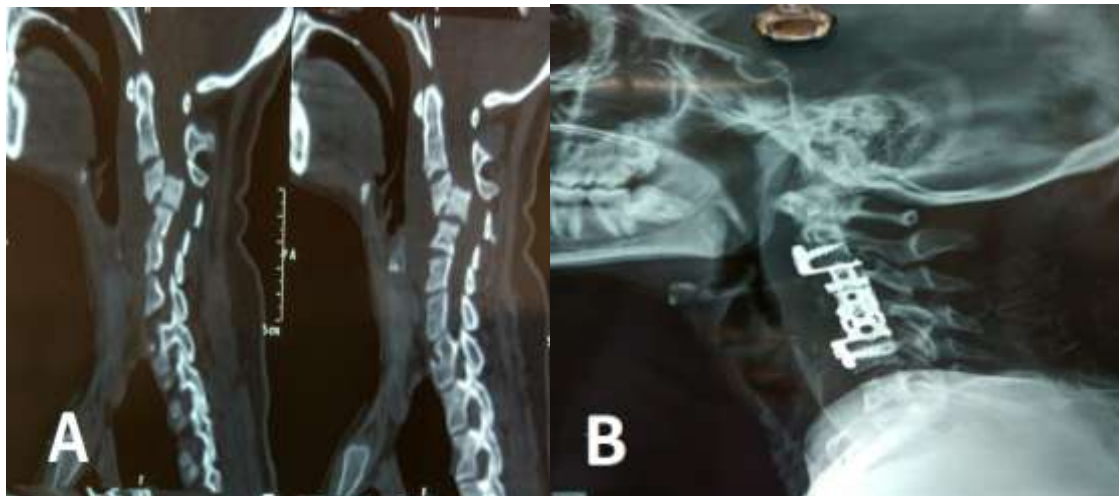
Pre-operative CT (A) and Post-operative (B) Radiograph images of a 34 years old patient with spinal tuberculosis who underwent C4-C5 corpectomy followed by cage with screw fixation.
